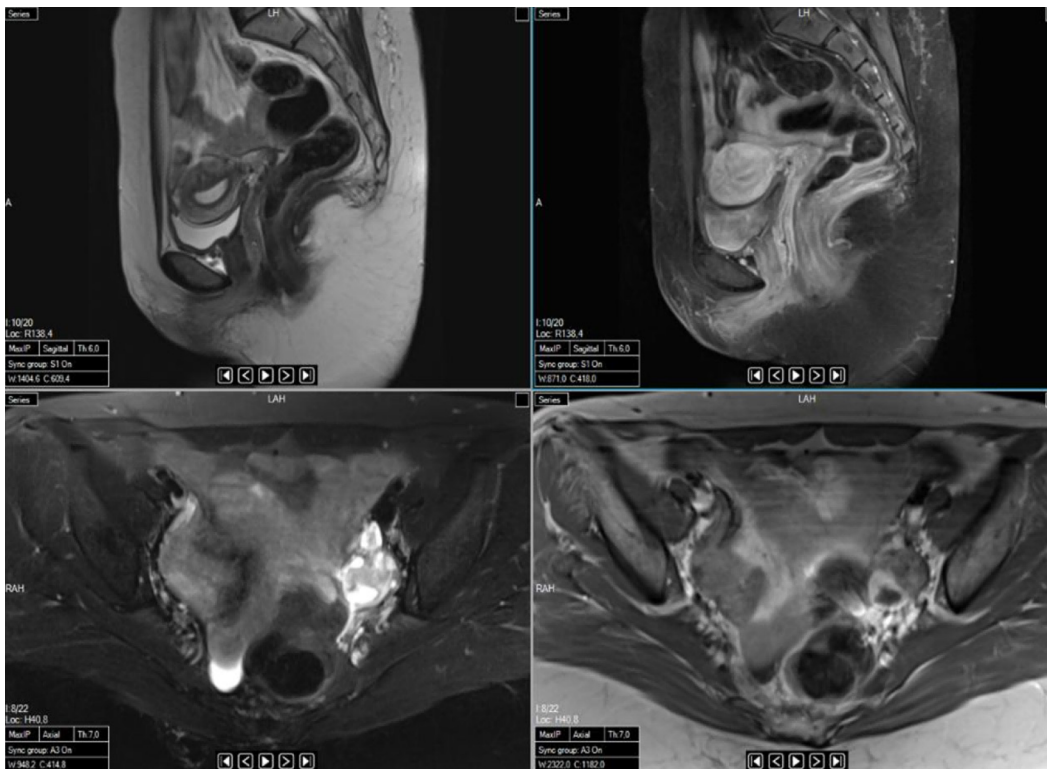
Sagittal and axial magnetic resonance images taken after resectioning the cystic teratoma shown in Figure 4.
